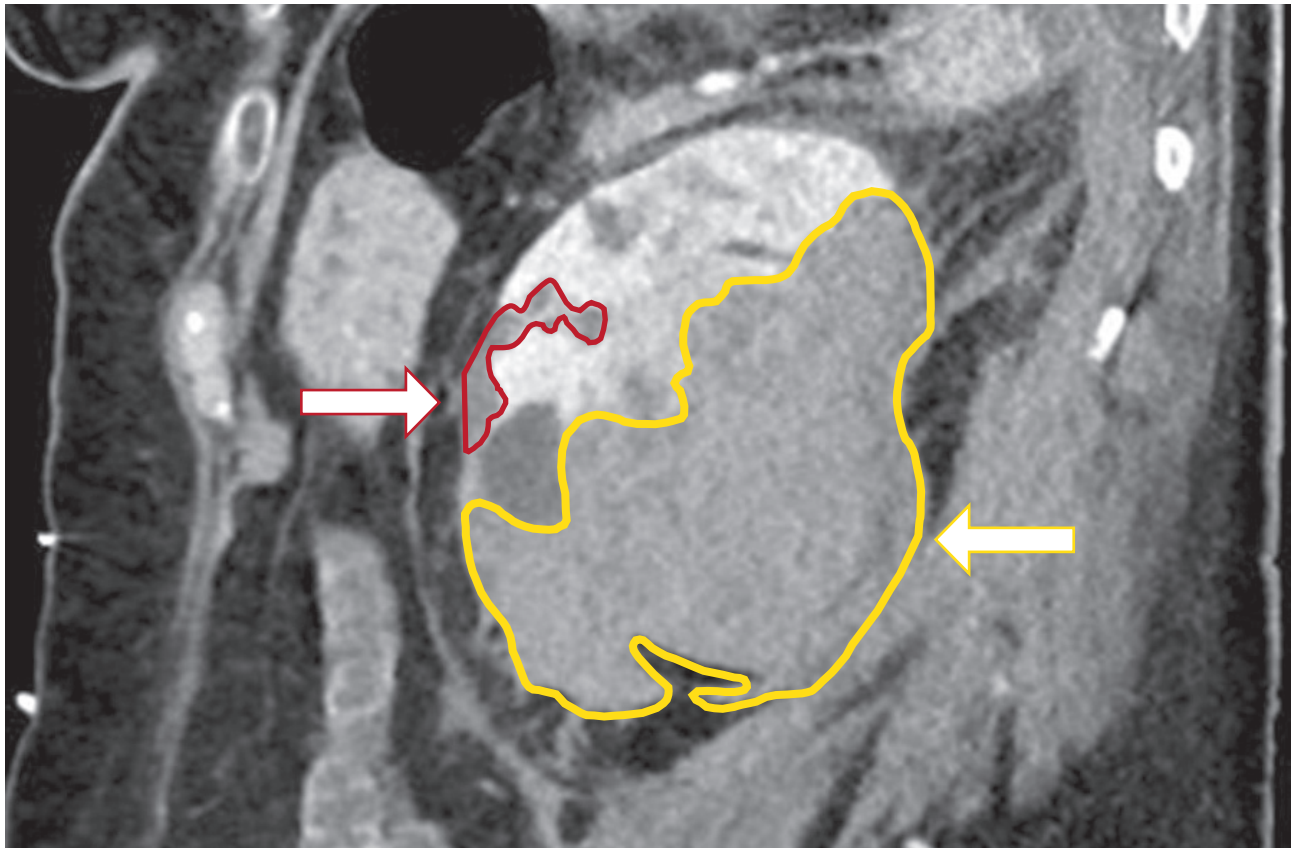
Abdominal computed tomography (sagittal plane) revealing extensive left perirenal haemorrhage (yellow outline; yellow arrow) and left upper renal rupture (red outline; red arrow)
